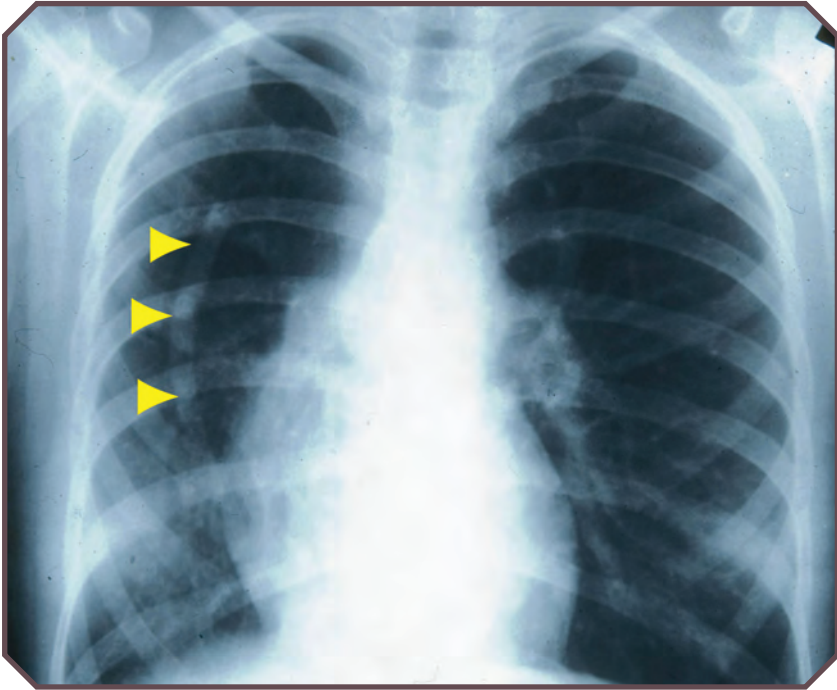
Frontal radiograph in a 2-year-old boy with Scimitar syndrome demonstrates hypoplasia of the right lung, dextroposition of the heart, and an anomalous draining vein (arrowheads).
